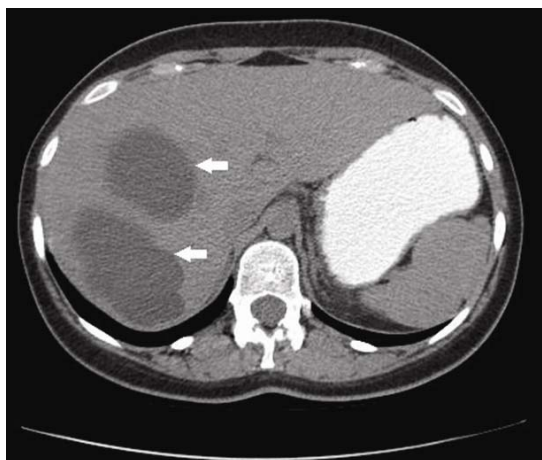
CT scan revealed two large cysts in the right lobe of the liver (white arrow).
